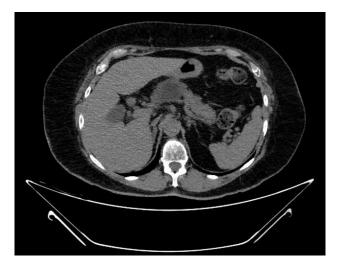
Four-week follow-up CT scan on the cross-sectional plane showed good radiologic response with an avascular area in the head of the pancreas corresponding to the ablation zone.
